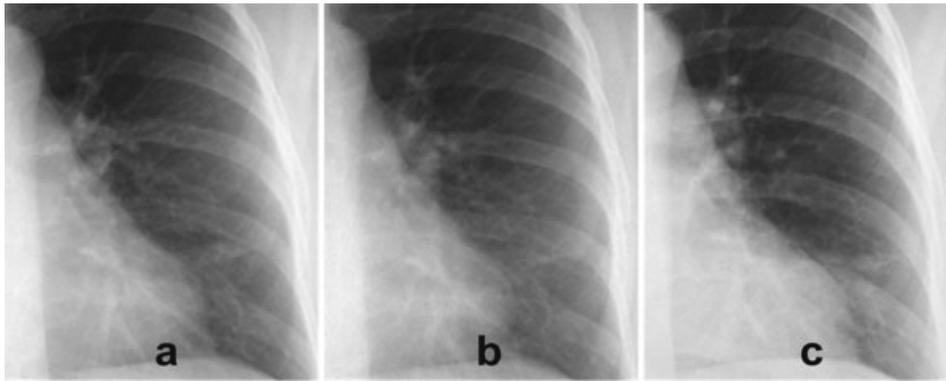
Images of the left lower lung demonstrates the potential of dose reduction of direct radiography (DR) as compared with computed radiography (CR, powder). Image b (DR) was obtained with 50% of the dose compared with a (DR) and c (CR).
